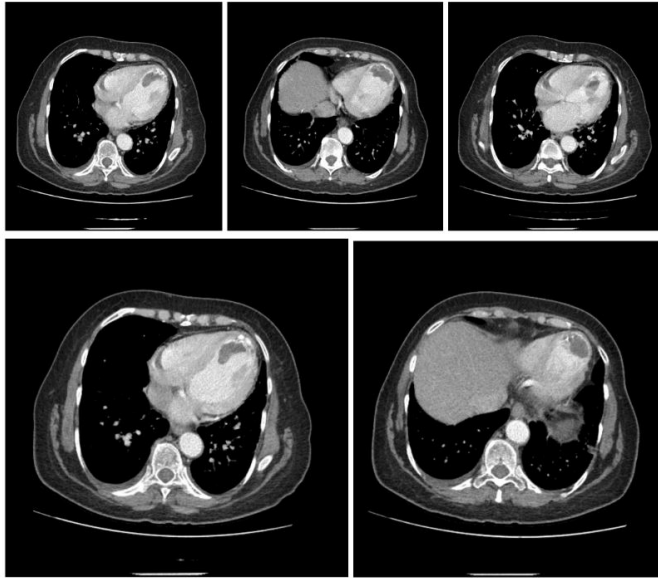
Chest CT taken on the 10th day of hospitalization; a view of the newly developed thrombus localized to the left ventricular apex
